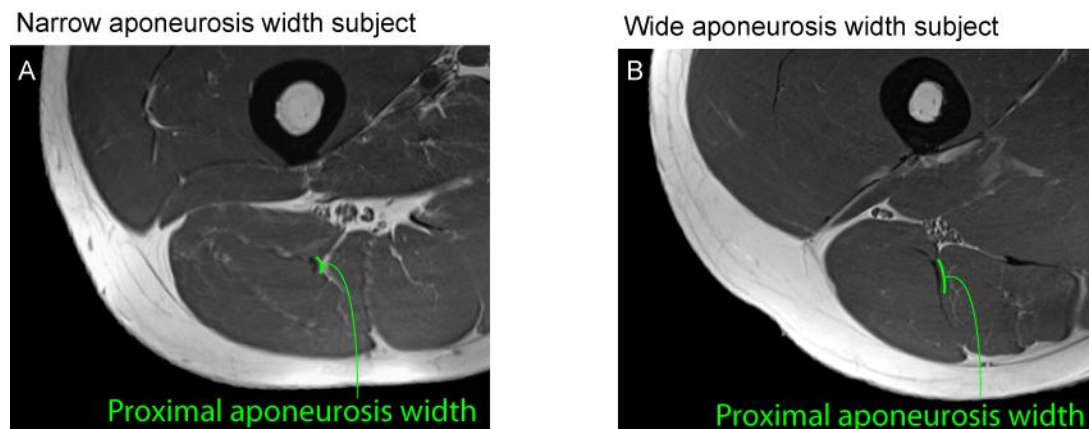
Example MR images of variable aponeurosis dimensions
